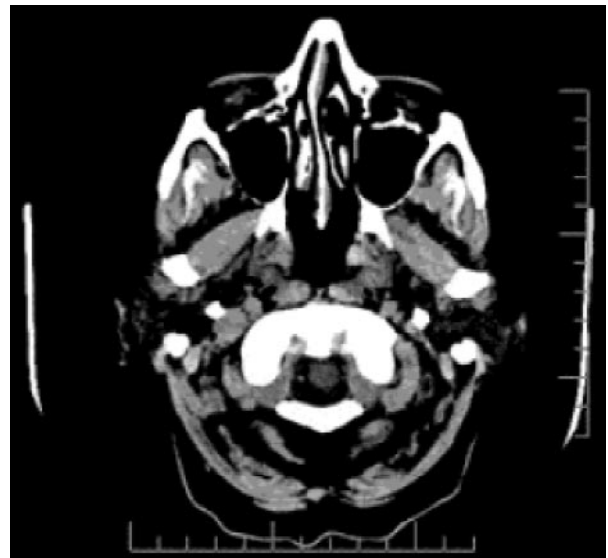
A CT image showing the structures of the brain
